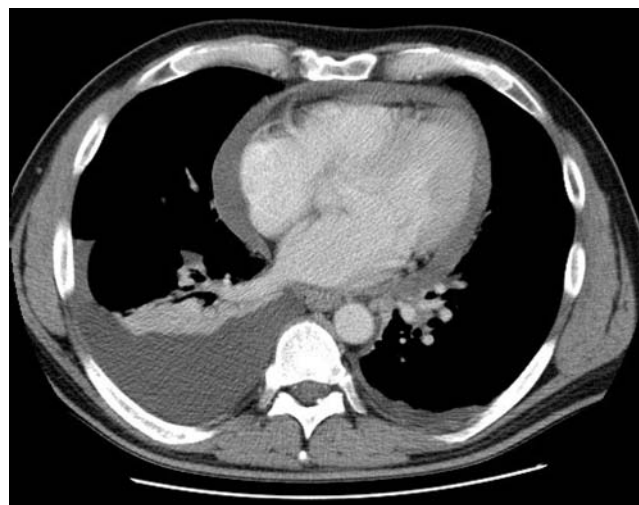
Computed tomography demonstrates right pleural and pericardial effusions, for which a right thoracoscopic approach is ideal.
